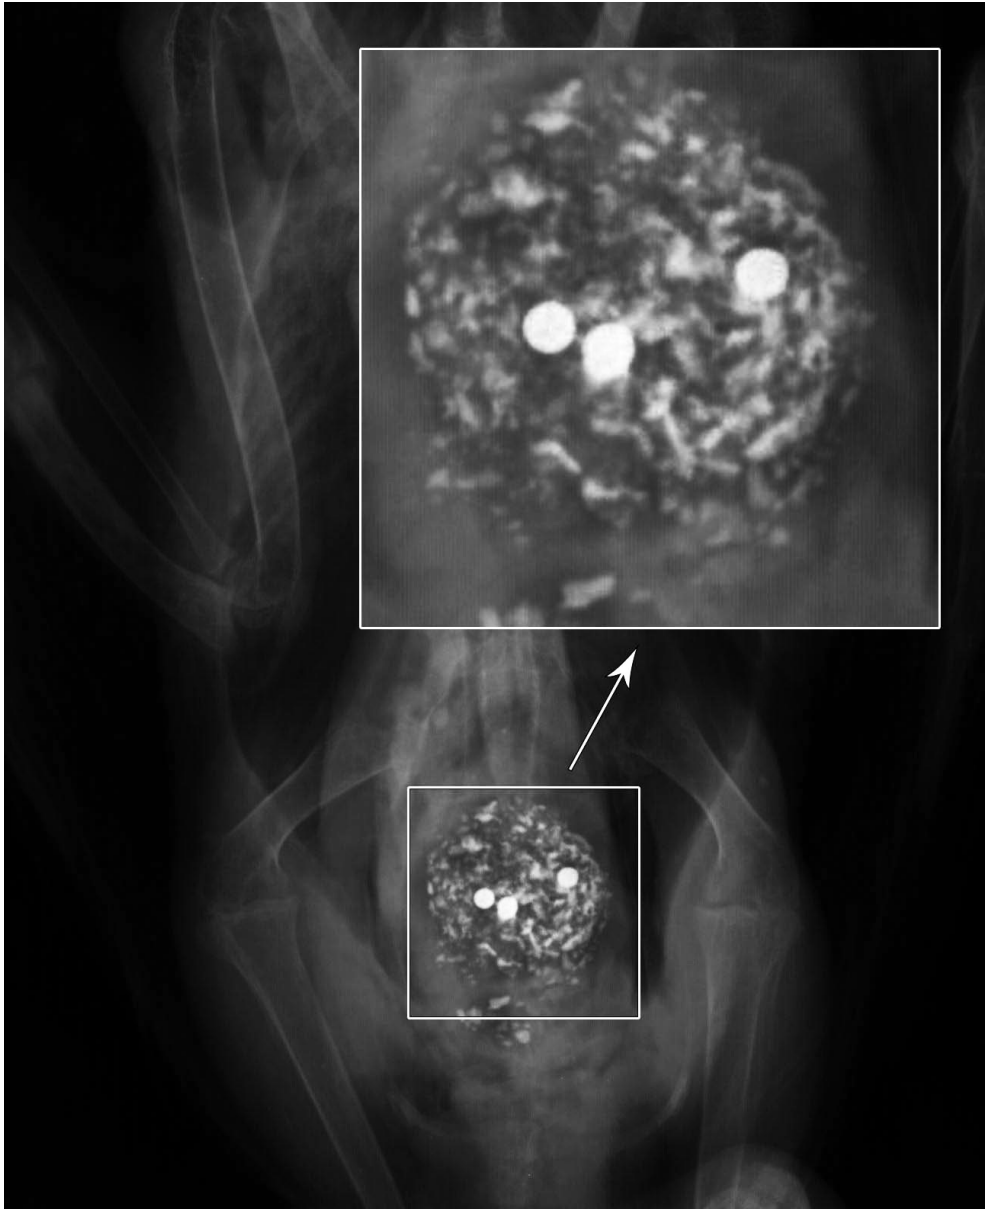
X-Ray of a dead mallard on the 21st day after it had been orally dosed with three lead pellets #3. The pellets permanently remained in the gizzard decreasing in diameter and eroding asymmetrically
